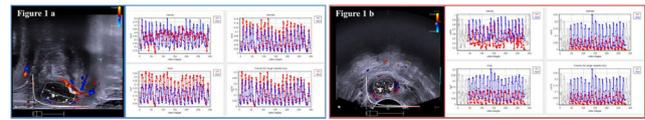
Endovaginal ultrasound with a biplane 12-MHz transducer (type 8848, B–K Medical) using linear array. Two region of interests are defined: midsagittal plane midurethra (Figure 1a); axial plane midurethra (Figure 1b). Analysis of the vascular parameters with the Pixel Flux software in the midsagittal plane (Figure 1a) and in the axial plane (Figure 1b).
